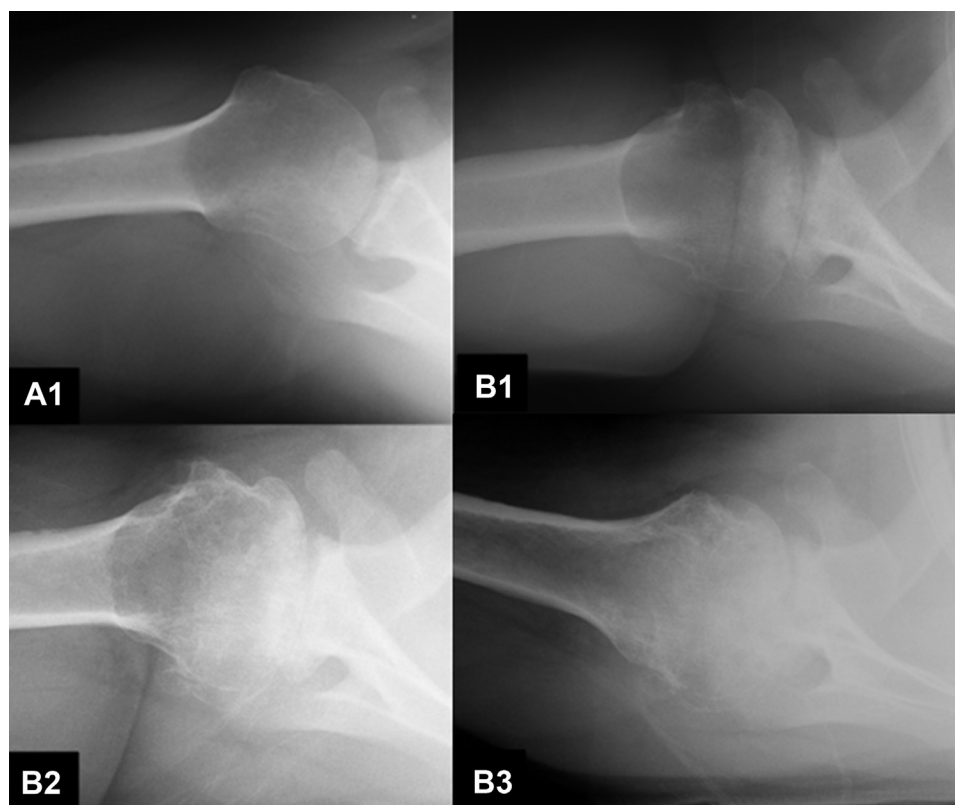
An example of how glenoid morphology progressed over roughly an 8-year period of time from an A1 glenoid to a B3 glenoid. The patient was a 43-year-old male (body mass index 26.6) at initial presentation for symptomatic right shoulder osteoarthritis and went onto an anatomic total shoulder arthroplasty. From presentation to year 5, the glenoid morphology remained A1 with 3 intervening radiographs documented. At year 6, the patient was noted to have a B1 glenoid (top right), a B2 glenoid at year 7 (bottom left), and a B3 glenoid at year 8 before proceeding with surgery (bottom right).
